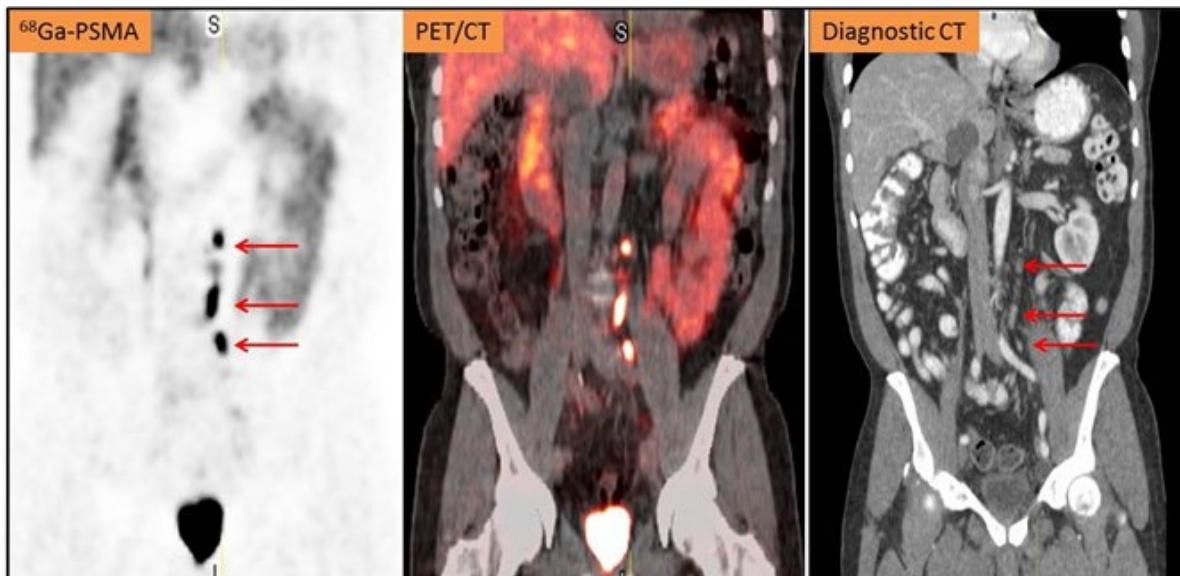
S/p prostatectomy (Gleason 4+4) and gradual PSA increase over 3 years to 11.2 ng/mL. Bone scan and diagnostic CT negative. 68Ga-PSMA shows positive retroperitoneal lymph nodes. Biopsy resulted positive for metastatic disease.
